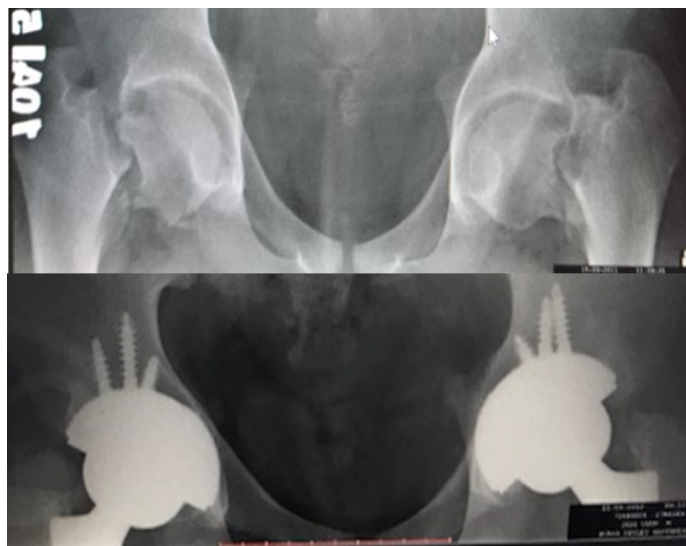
Pre- and post-operative radiographs of the patient showing bilateral femoral neck fractures
